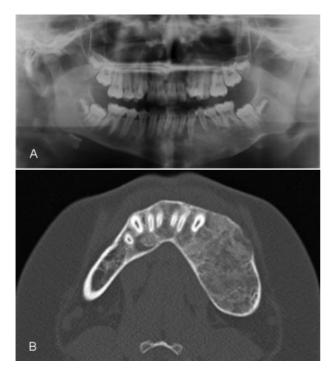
Postoperative X-ray images after 12 weeks of treatment: (A) Panoramic and (B) CT images showing good final results with complete ossification of the lytic areas and no signs of recurrence. CT, computed tomography.
